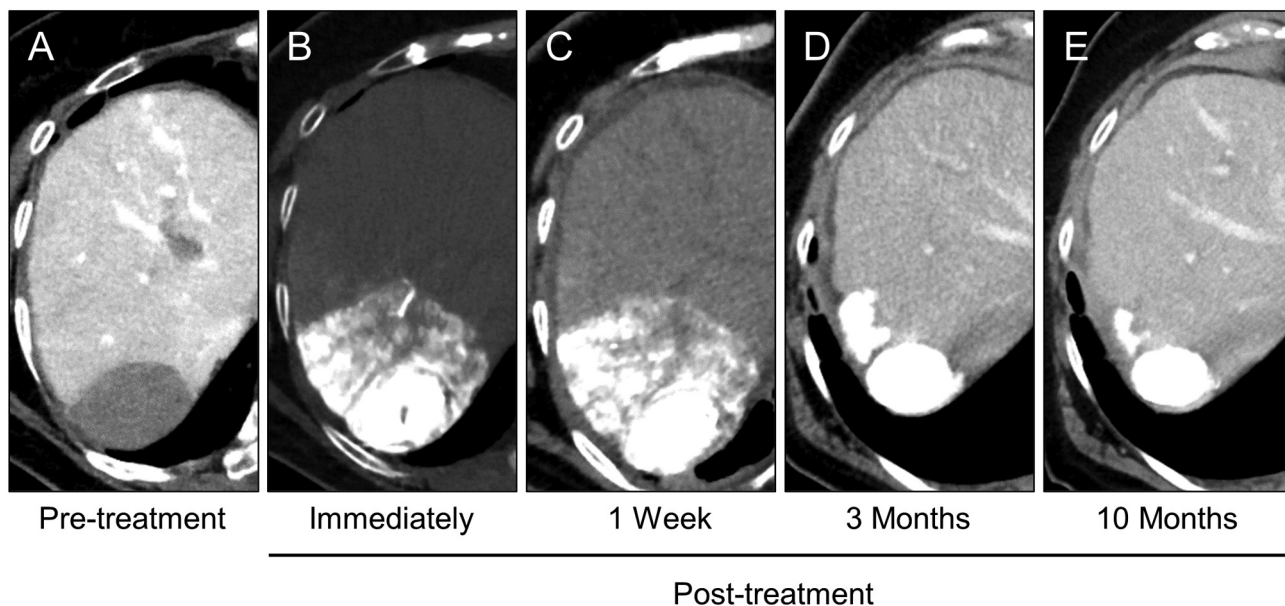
Representative case of transarterial chemoembolization using a glass membrane pumping emulsification device. A 45 mm hepatocellular carcinoma was treated by transarterial chemoembolization using a glass membrane pumping emulsification device. A total of 4.5 ml of the emulsion was injected into the tumor-feeding artery, followed by embolization using 1-mm gelatin particles. A: Computed tomography (CT) during arterial portography showed contrast defect at segment 7 in the liver. B: Plain CT showed suitable deposition of ethiodized oil surrounding the tumor at the end of the treatment. C: Plain CT also showed ethiodized oil retention 1 week after the procedure. D and E: Contrast-enhanced CT showed complete response in the target nodule at 3 (D) and 10 (E) months after the treatment.
